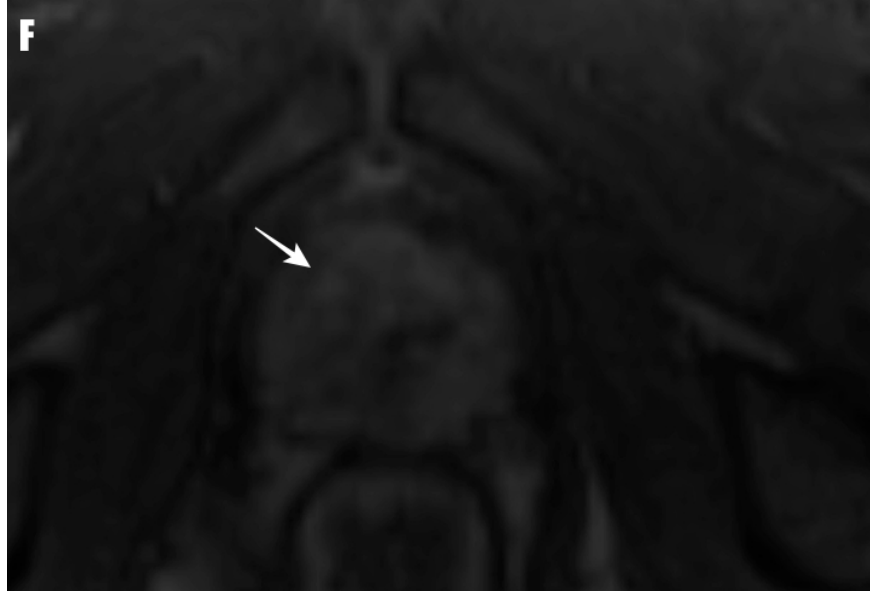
67-year-old man with prostate-specific antigen level of 8.31 ng/mL. Arrows present Prostate Imaging Reporting and Data and System (PI-RADS) category 5 lesions visible in the peripheral zone. A , Axial T2-weighted MR image shows lesion in the right-apex peripheral zone. The dimension of the lesion is 2.0 cm which is consistent with the PI-RADS score of 5 on T2-weighted image. B ,C, show that the lesion is hypointense on DWI($b=50 \text{ s/mm}^2$) and hyperintense, on DWI($b=1800 \text{ s/mm}^2$). D , Apparent Diffusion Coefficient map, indicates that the lesion is significantly hypointense, making it PI-RADS score of 5 on DWI. E (precontrast T1-Weighted) and F, Dynamic contrast enhancement MR image shows early enhancement within same location as lesion in A–D with early enhancement for overall PI-RADSv2.1 score of 5. TRUS-guided cognitive MRI fusion biopsy is detected prostate cancer with ISUP 5.
